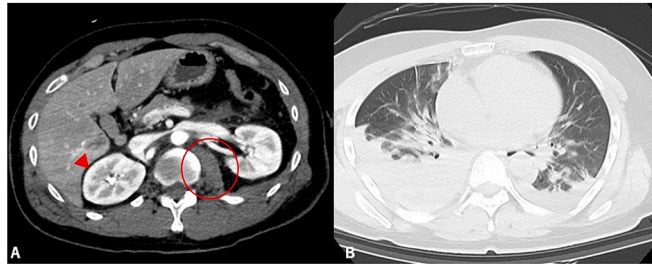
On admission, abdominal CT showed liver injury (arrowhead) and left retroperitoneal haematoma (circle) (A). Chest CT showed bilateral haemothorax with a right-sided predominance (B). CT, computed tomography.
